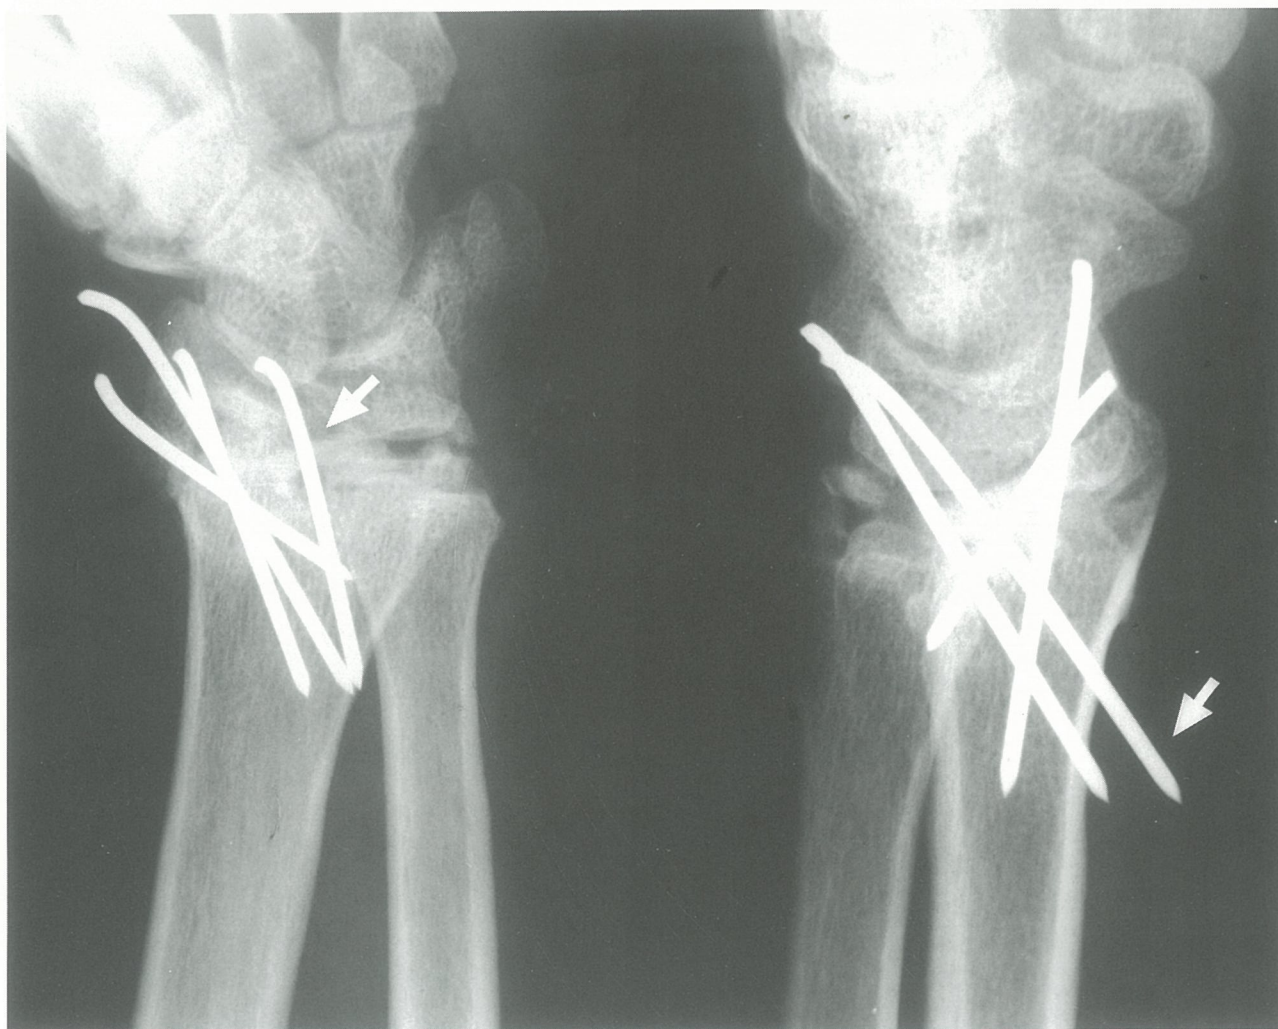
Magnified views of the initial radiograph at 3 months follow-up
